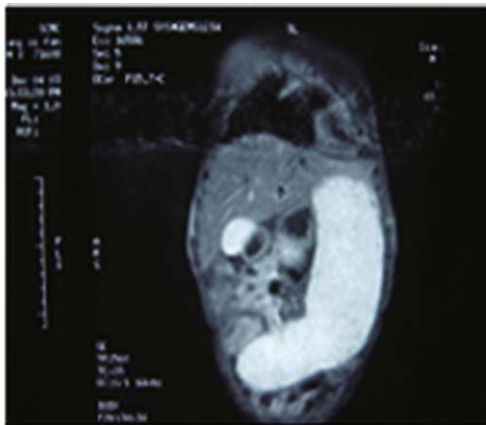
MRI of coronal T1-weighted image after contrast showing a huge spleen in the pelvis with homogeneous enhancement.
